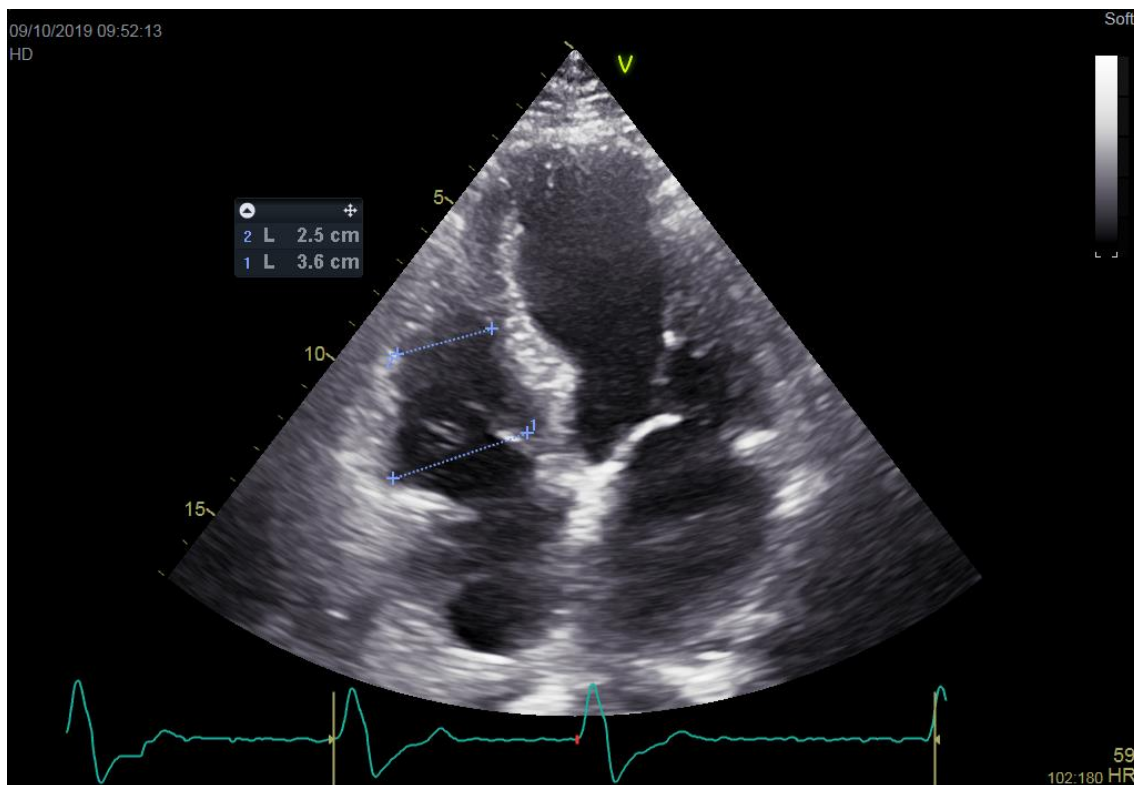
Echocardiographic image from apical 4-chamber view showing the right ventricular (RV) end-diastolic basal (L1) and mid (L2) diameters. The transducer is adjusted to focus on the RV chamber, with the goal of maximizing RV chamber size.
